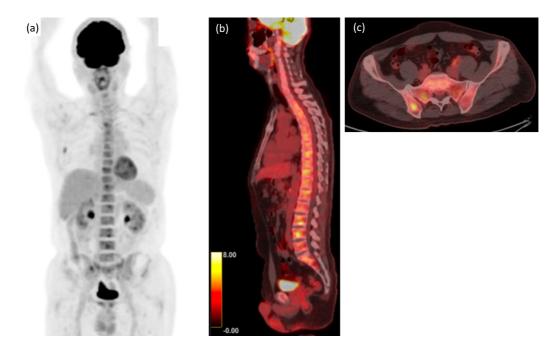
The findings of PET/CT at the time of health checkup. Maximum intensity projection PET image (a) and PET/CT images (b, c). PET/CT showed the diffuse but focally inhomogeneous uptake of ¹⁸F-FDG. The SUV_{max} of right ilium was 6.3.
